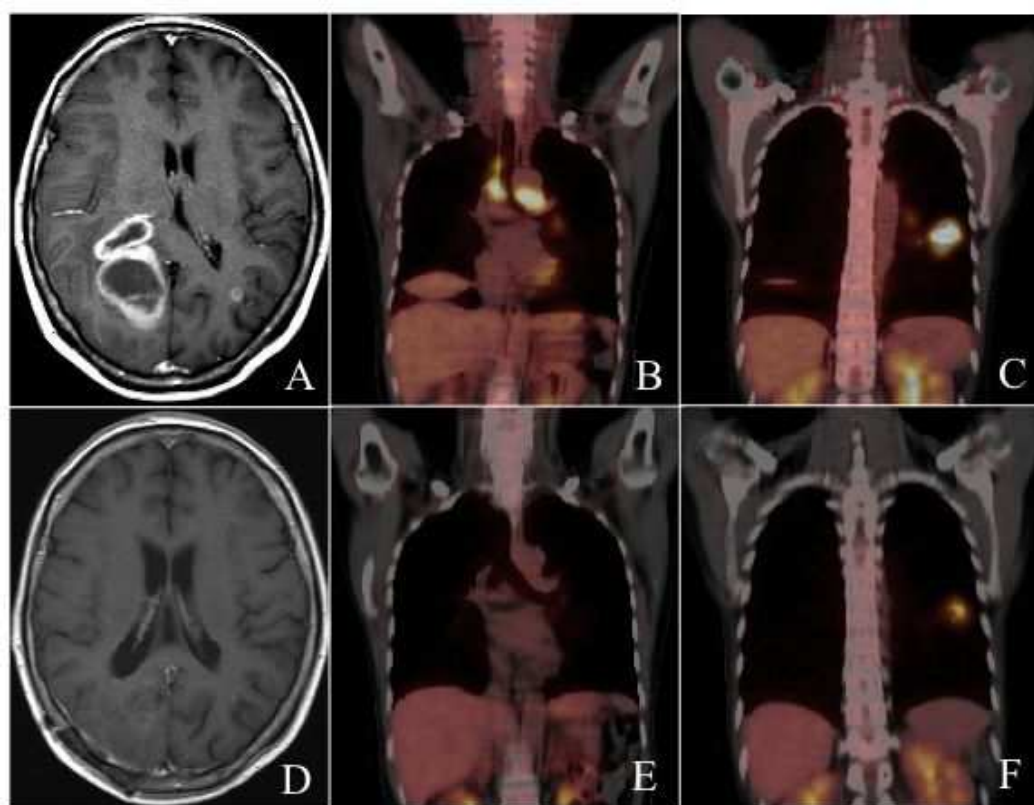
A) Contrast-enhanced MRI findings before treatment. A total of six metastases are seen, including a lesion ≥ 4 cm in diameter with ventricular invasion in the right occipital lobe. (B,C) Preoperative FDG-PET examination. Multiple metastases are seen in the lungs. (D) Contrast-enhanced MRI after treatment. All of the multiple lesions have disappeared. (E,F) FDG-PET examination following systemic chemotherapy. The lesions in the lungs are markedly reduced in size.
